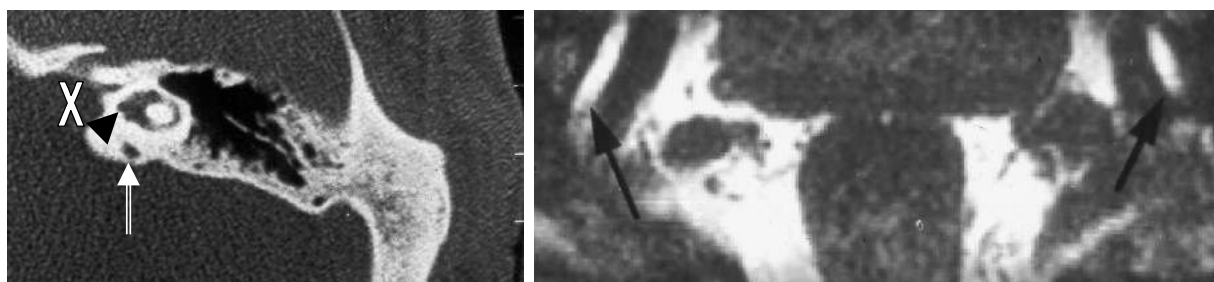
Left panel:* CT scan of the left ear in the (transverse) axial plane of patient B. A widened internal meatus is visible ("X") as well as a plump vestibule (arrowhead). The vestibular aqueduct (arrow) is widened. *Right panel:* Coronal reconstruction of 3D high-resolution MRI showing an enlarged endolymphatic duct (arrows) on both sides of patient B at the age of 28 years.
